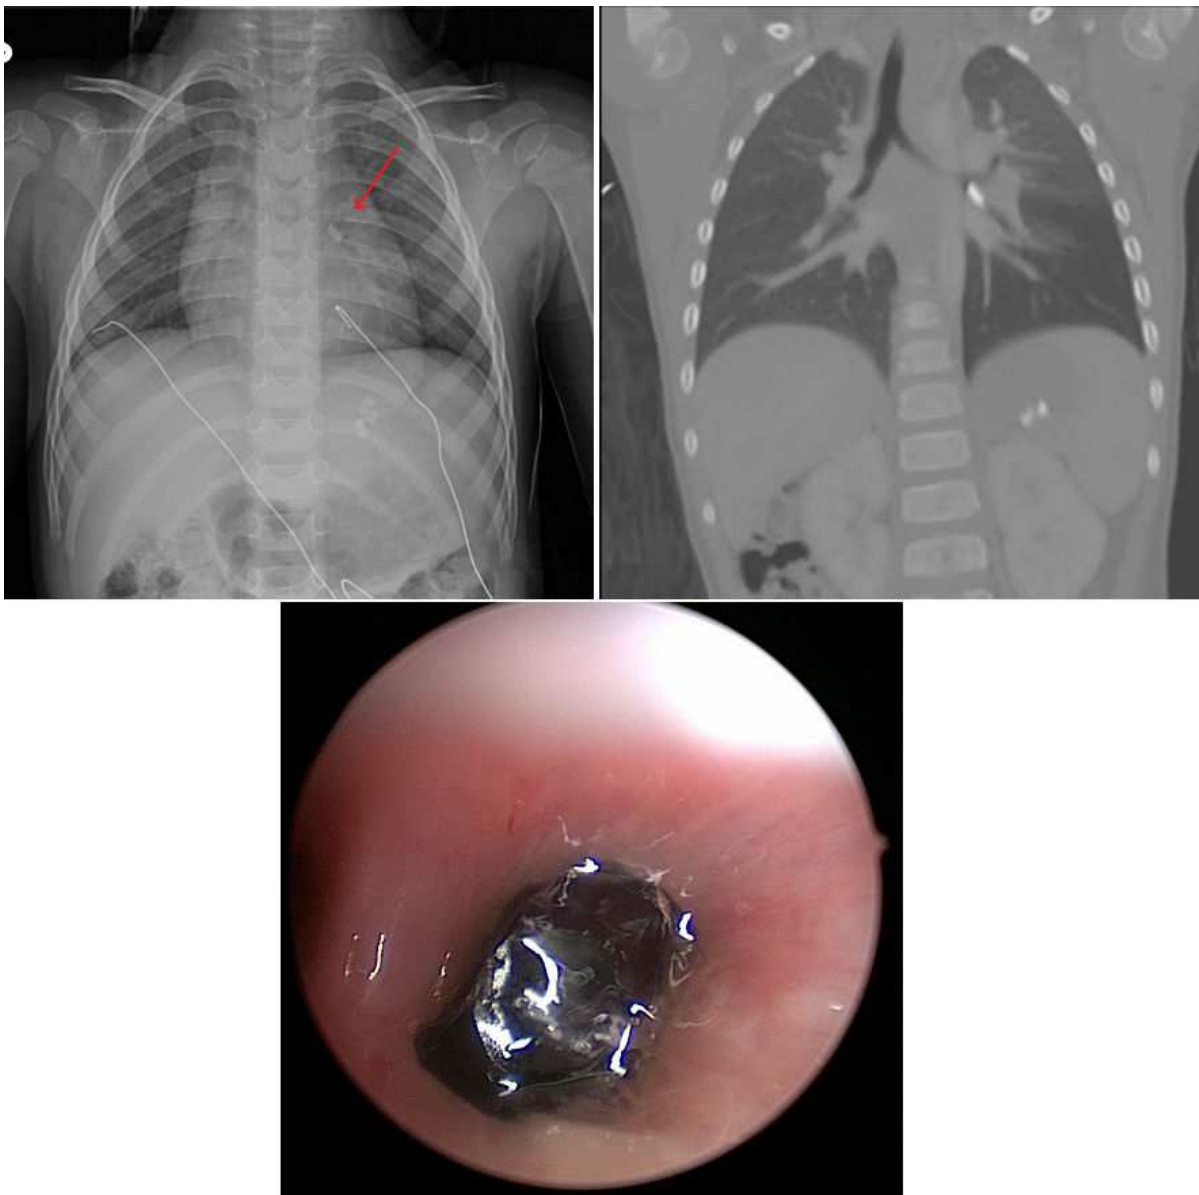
A 2-year-old patient presented to the Emergency Department with multiple facial lacerations following a motor vehicle accident during which she was ejected through the passenger side window. She had no respiratory symptoms as presentation. As part of her trauma workup, she underwent both plain film and CT imaging of the chest, both showed a possible left-sided airway foreign body. Direct laryngoscopy with bronchoscopy confirmed the diagnosis, and the object was endoscopically removed without difficulty.
